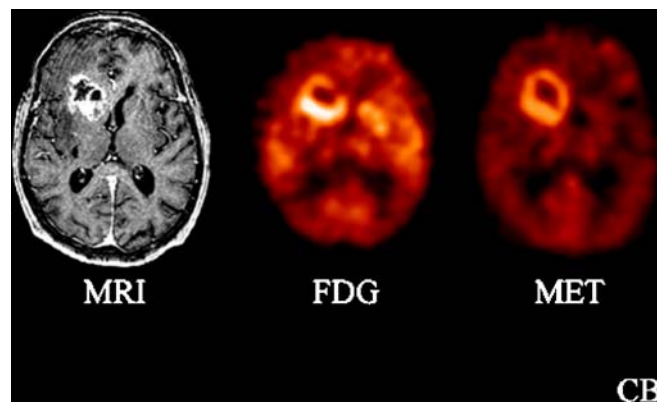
GBM. The contrast-enhanced T1-weighted MR, co-registered images of F-18 FDG and C-11 methionine in a proven case of glioblastoma multiforme. Contrast-enhanced areas show good FDG and Met uptake.
